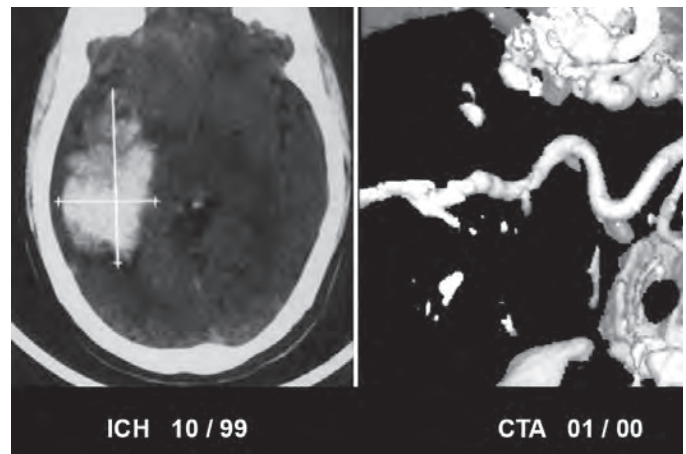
CT scan showing intracerebral haematoma and CT angiogram demonstrating AVM
